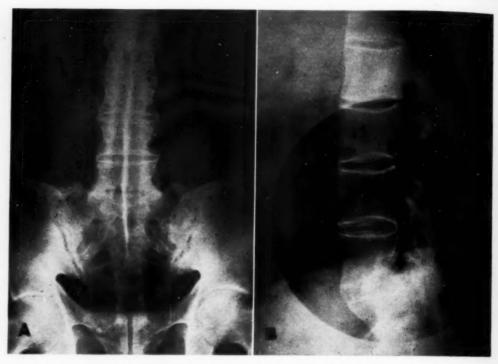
A. "Bamboo spine" with calcification of ligaments between spinous processes. This roentgenogram is most unusual because the sacroiliac joints, although involved, are not ankylosed. The sacroiliac joints are almost always completely ankylosed when extensive ligamentous calcification is present. B. Lateral view demonstrating calcification and/or ossification of all the spinal ligaments, including the ligamenta flava. The apophyseal joints are ankylosed. The intervertebral disks are well preserved. Note the straight lumbar spine.
